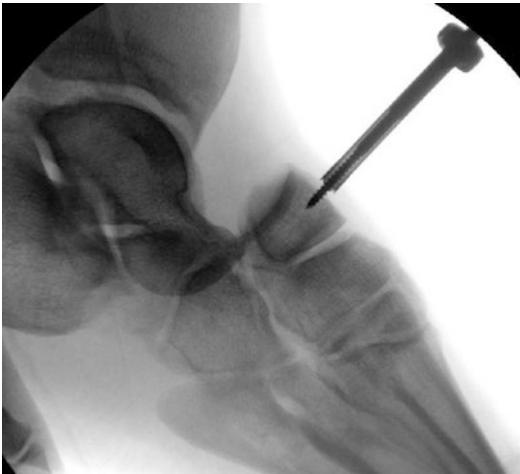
Lateral radiograph with 4.0 mm Schanz pin in the navicular, which was used as a manipulation tool
